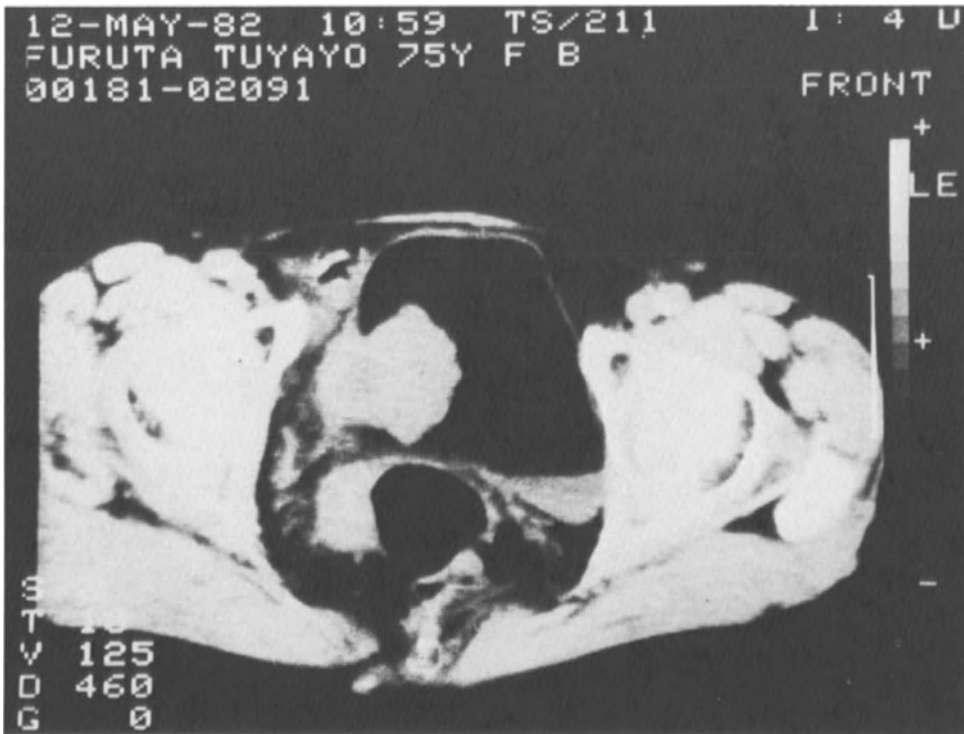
CT scan of Case No. 2 showing urinary bladder cancer before chemotherapy (M. Kakehi, et al., 89).
